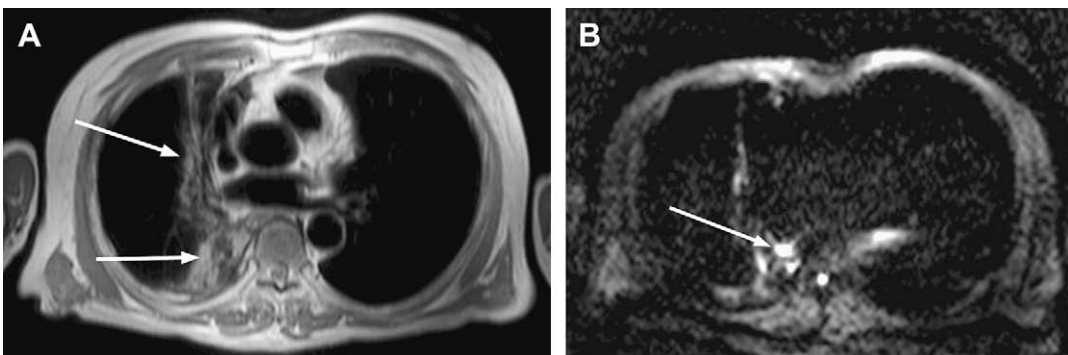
Patient with lung cancer status post radiation therapy. T1-weighted image (A) show parenchymal changes from radiation therapy but no definite evidence of residual tumor. Breath hold DW image (B) b-value 500 s/mm^2 shows a small focal nodule with marked restriction of water diffusion. Findings represent tumor recurrence and correlated with results of subsequent PET scan (not shown).
